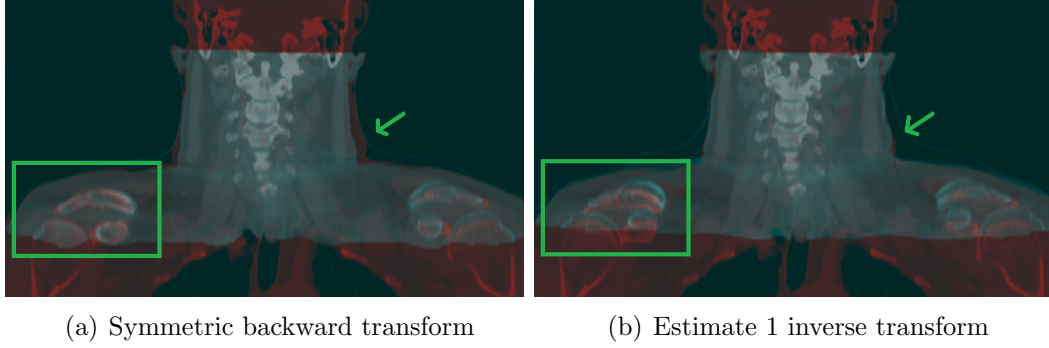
Coronal plane images of patient K showing an overlap between pCT (red) and deformed CBCT (cyan). Registration was performed using a (a) symmetric and (b) an estimate the inverse transform. Estimating the inverse transform shows a better alignment of soft tissues (green arrow) and backward symmetric shows a better alignment of bone structures.
